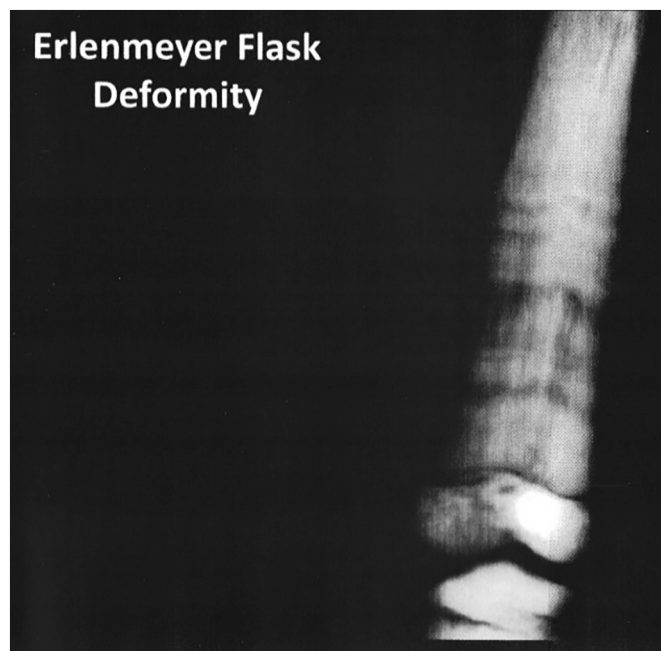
Classic Radiographic Features of Albers-Schönberg's Disease. This radiograph of a distal femur shows the changes of osteopetrosis reported in 1904 by Albers-Schönberg: [1] skeletal opacity, absence of trabecular structure as well as the medullary cavity, and impaired bone modeling later called "Erlenmeyer flask deformity" [3]. The "rings" of osteosclerosis perpendicular to the bone surface are striking, reminiscent of the "zebra lines" caused by anti-resorptive treatment when given intermittently to children with osteogenesis imperfecta, and suggest cyclical disease activity.
